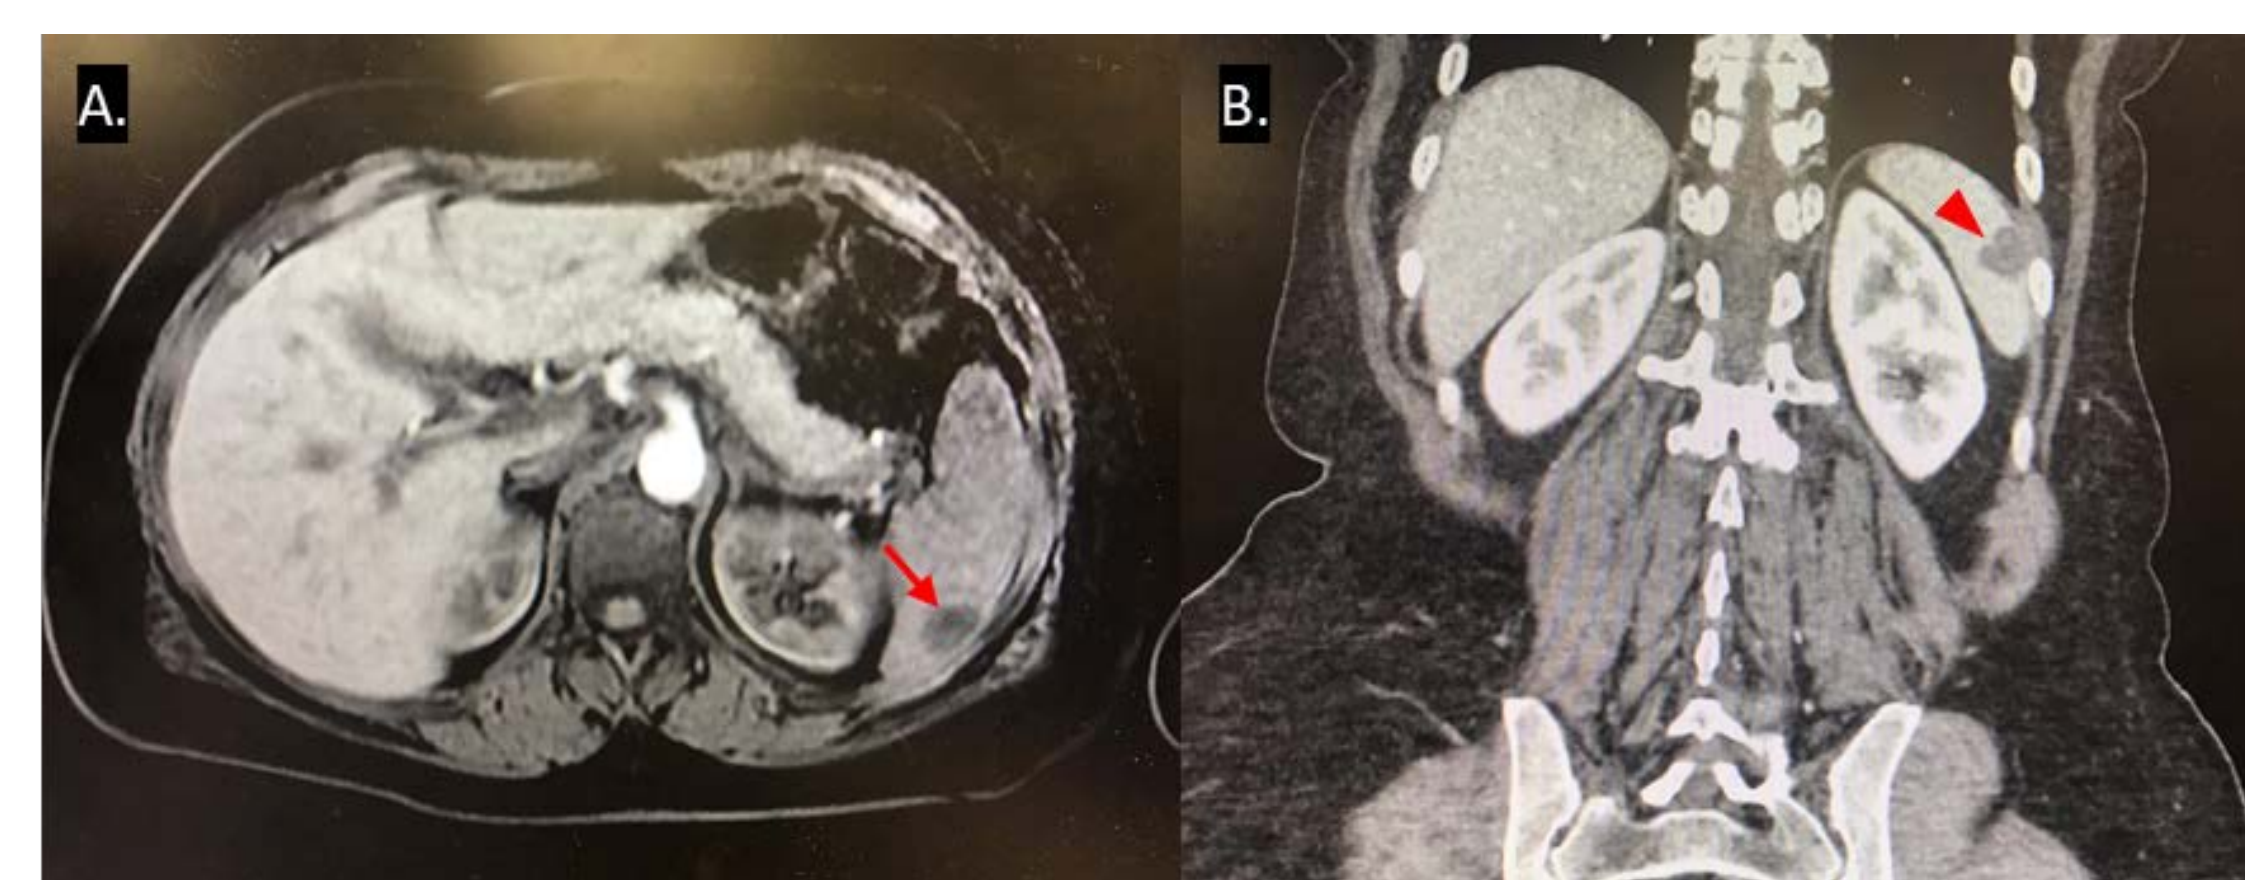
A hypo-enhancing splenic mass is seen in T1-weighted MRI of the abdomen (arrowhead, B).
